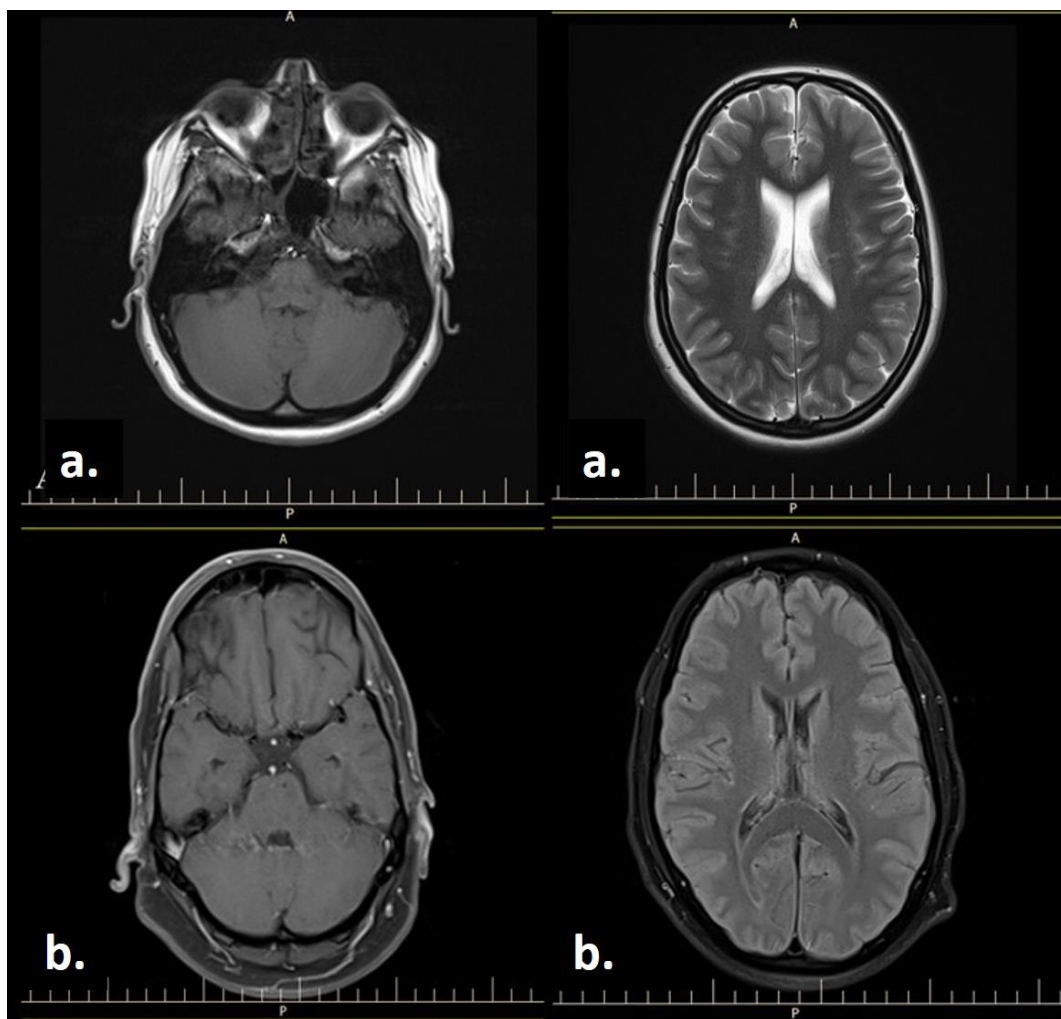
Brain MRI Image Showing no Restricted. Left (a, b) for Case 1. Right (a, b) for Case 1.
